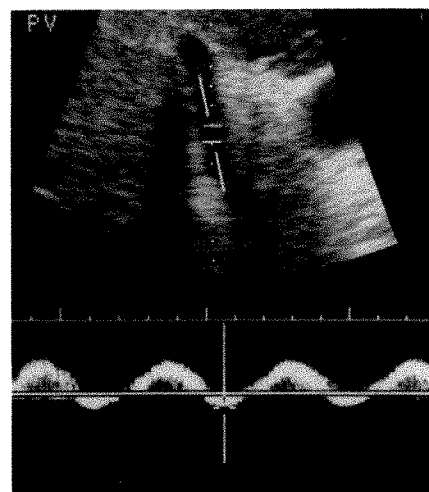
Portal vein duplex Doppler sonogram in tricuspid regurgitation shows pulsatile waveform with retrograde flow presumably during systole.
